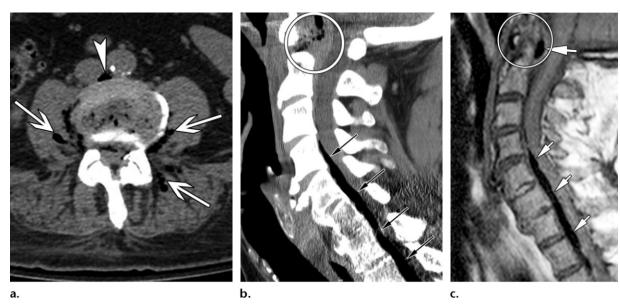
Necrotizing soft-tissue infection and emphysematous osteomyelitis in a 57-year-old man with septicemia. CT of the abdomen was performed to search for the source of infection. (a) Axial nonenhanced CT scan of the abdomen shows perivertebral soft-tissue gas (arrows) in the adjacent psoas and erector spinae muscles and a focus of gas (arrowhead) in the retroperitoneum insinuating between the abdominal aorta and inferior vena cava. Also note the intramedullary gas within the vertebral body, as well as gas extending into the epidural space. (b, c) Sagittal CT (b) and T1-weighted MR (c) images of the cervical spine show that the source of infection is emphysematous osteomyelitis of the C1-C2 articulation with soft-tissue gas and swelling in and about the joint (circle). Extension of the epidural gas (arrows), characterized as low-signal-intensity foci, along the anterior cervical and thoracic spine is seen. These findings are consistent with necrotizing soft-tissue infection and emphysematous osteomyelitis.
